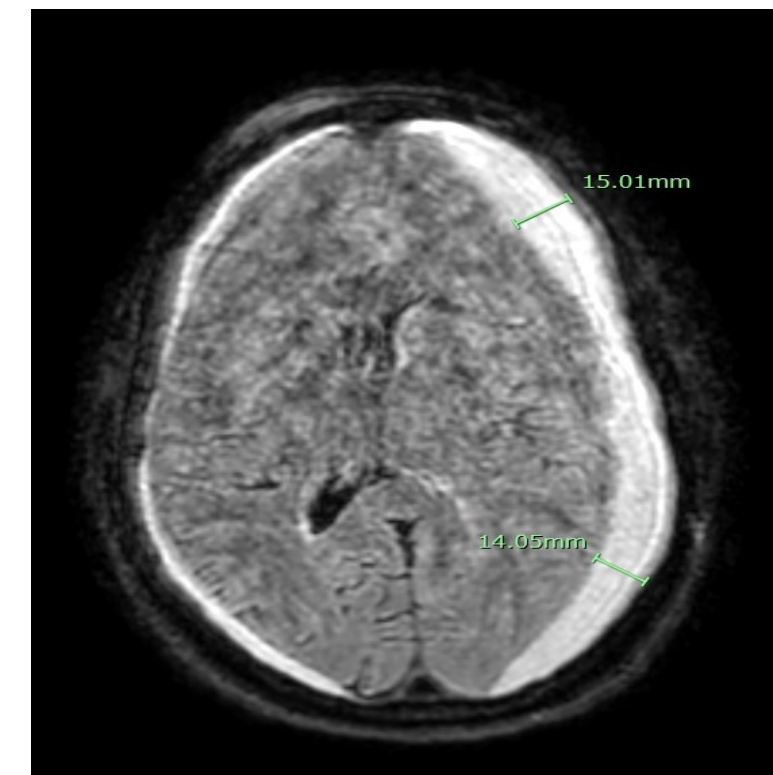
Admission day 2 CT scan with bilateral hematomas
